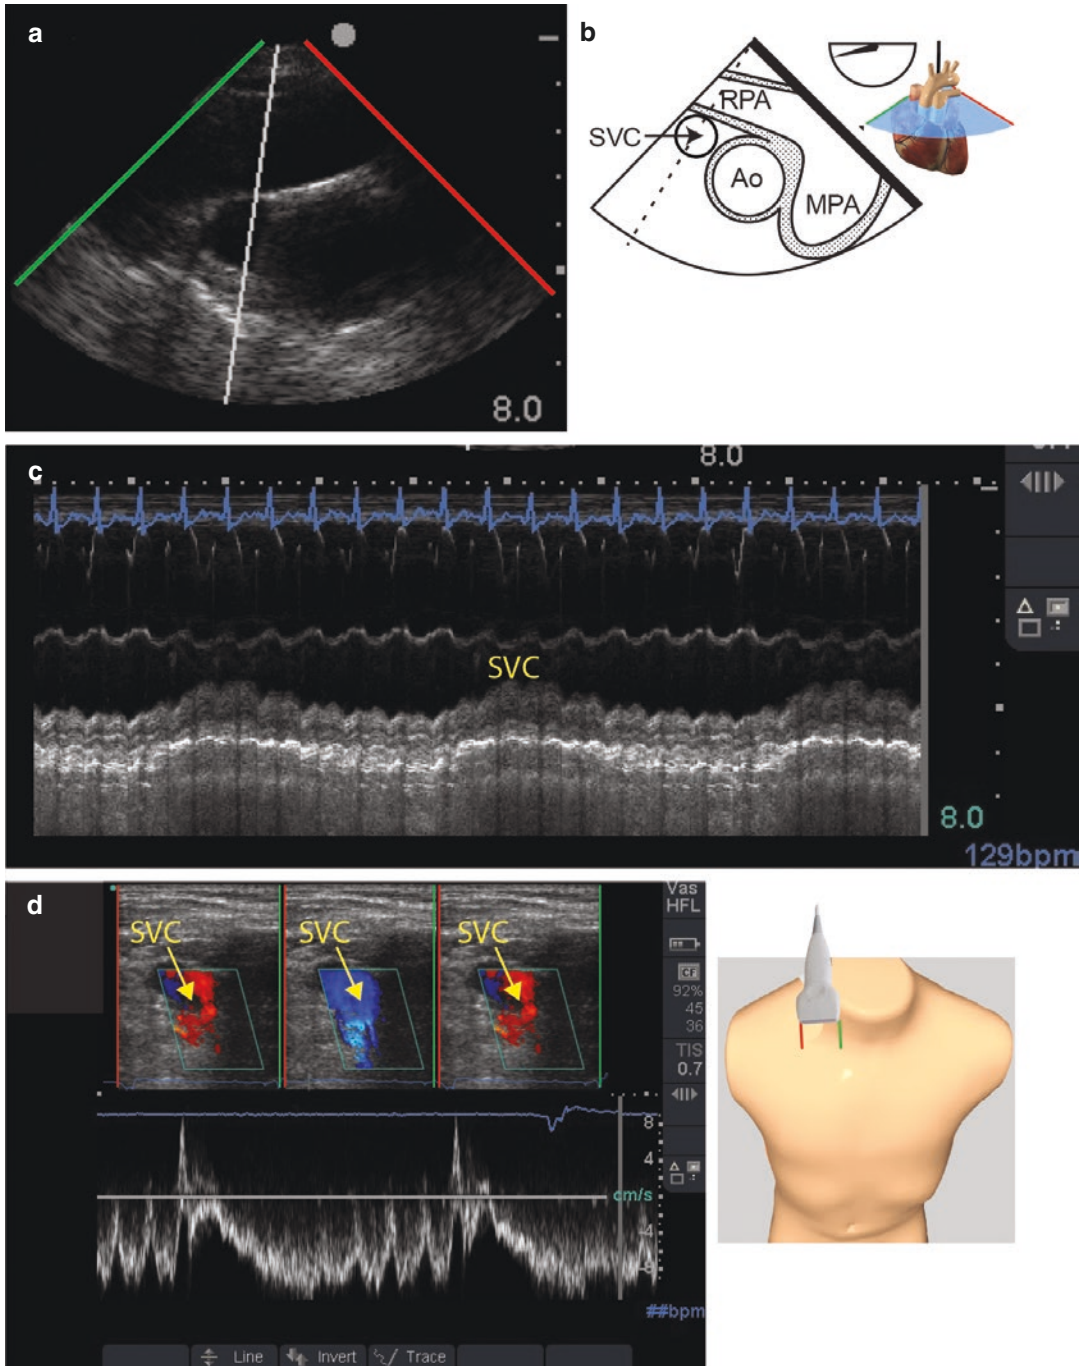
Respiratory variations of the superior vena cava (SVC). A 76-year-old male in the intensive care unit is dialyzed with planned fluid removal of 1.8 L. (a, b) The transesophageal mid-esophageal ascending aorta (Ao) short-axis view with (c) M-mode of the SVC shows significant respiratory variation of the SVC diameter. (d) With a linear probe positioned in the right cervical region
